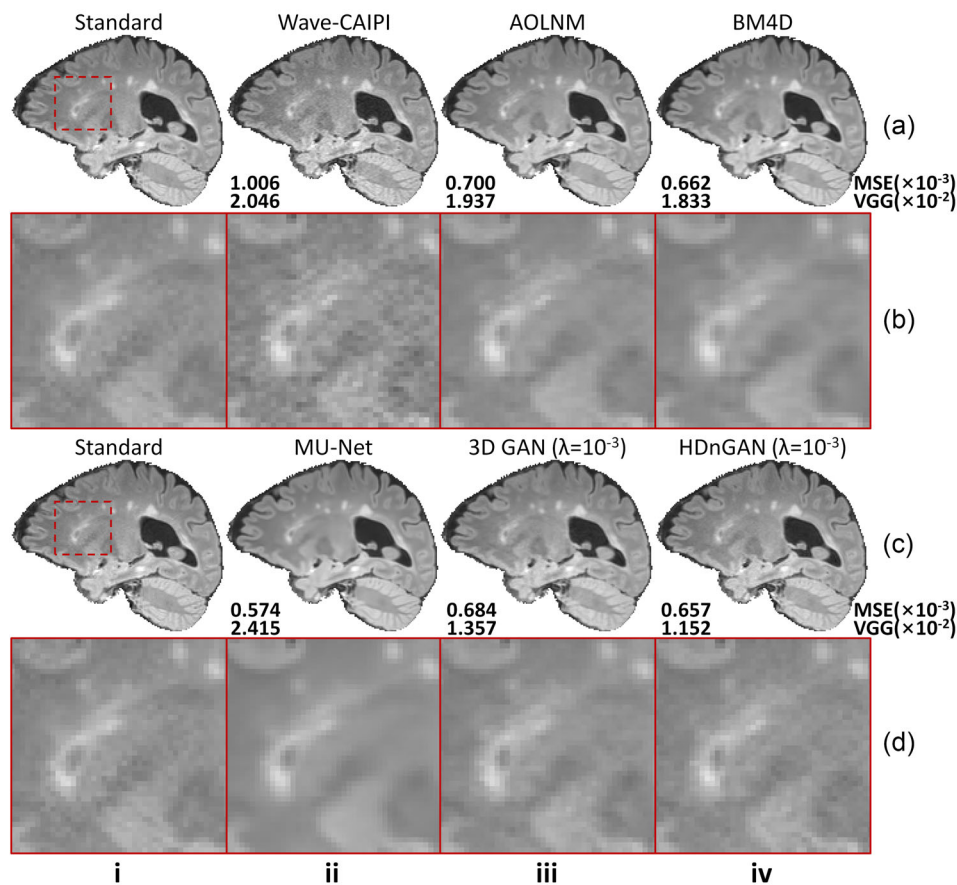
Visual comparison of results from different methods. Representative sagittal image slices (rows a and c) and enlarged regions (rows b and d) from standard fluid-attenuated inversion recovery (FLAIR) data (rows a, b, c, d, column i), wave-controlled aliasing in parallel imaging (Wave-CAIPI) data (rows a, b, column ii), adaptive optimized nonlocal means (AONLM)-denoised results (rows a, b, column iii), block matching with 4D filtering (BM4D)-denoised results (rows a, b, column iv), modified U-Net (MU-Net) results (rows c, d, column ii), 3D generative adversarial network (GAN) ($\lambda = 10^{-3}$) results (rows c, d, column iii), and hybrid denoising GAN (HDnGAN) ($\lambda = 10^{-3}$) results (rows c, d, column iv) from one evaluation subject. Image similarity metrics including the mean squared error (MSE) and VGG perceptual loss (VGG) are listed to quantify the similarity between images from different methods and the standard FLAIR image.
